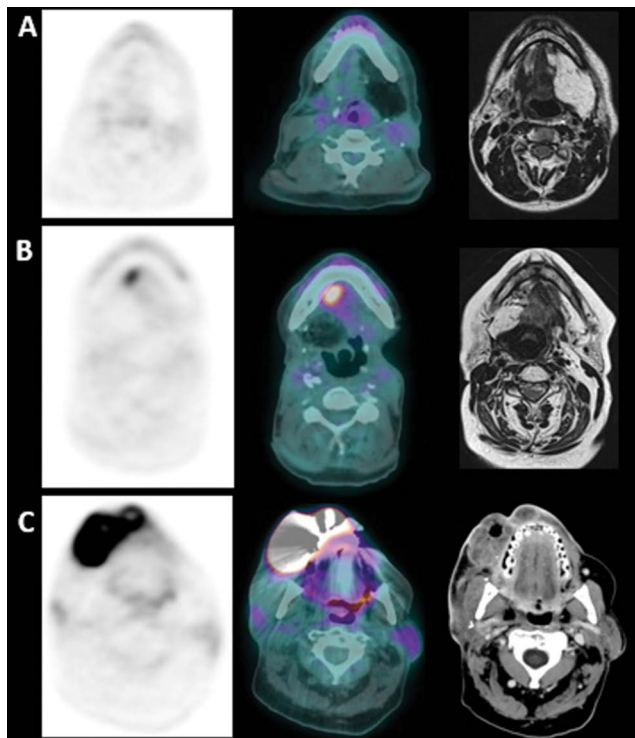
A. A representative case of type-A functional FDG uptake in the oral cavity (axial PET, PET/CT fused and contrast-enhanced images); B. in a 48-year old male treated for left-side tongue cancer. An example of type-B suspicious uptake on the left side in a 66-year old male treated for tongue carcinoma (axial PET, PET/CT fused and T-2 MRI images); C. A case of type-C FDG uptake on the right lip and cheek consistent with relapse (axial PET, PET/CT fused and T-2 MRI images)
